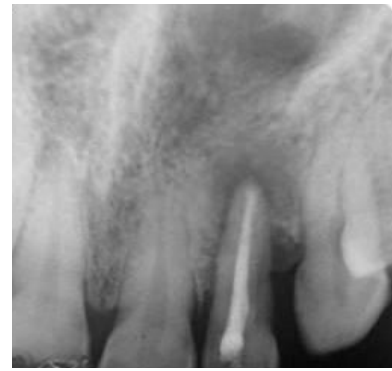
I(d).IOPA radiograph showing parapulpal line.
